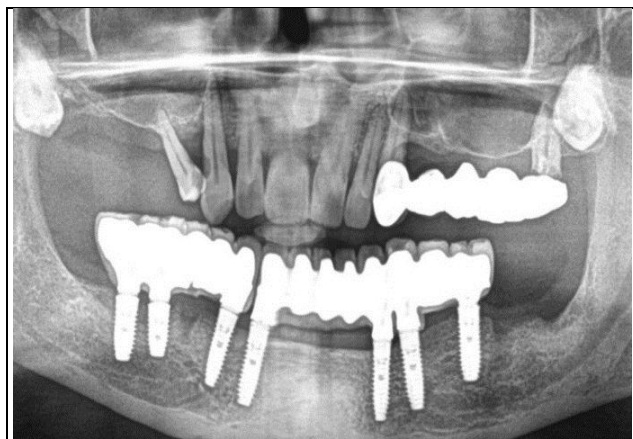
Post Rehabilitation Radiograph
